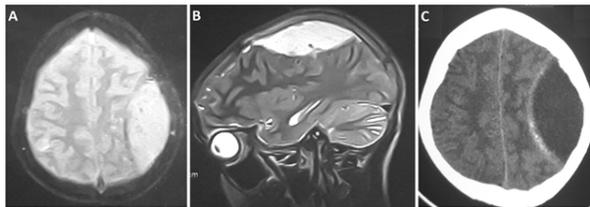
A- T1W MR axial image showing hyperintense mass in the extra dural space which is also hyperintense on T2W image (1B). C: Non-contrast CT showing large volume left (fronto-temporo-parietal) hypodense EDH with peripheral calcification.
